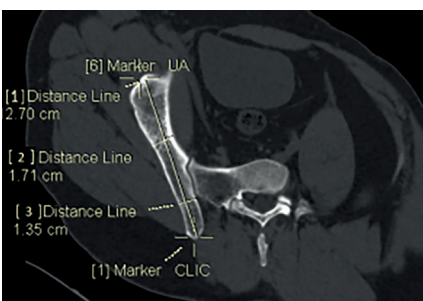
Path C [CLIC point to upper acetabulum (UA)]. Double oblique reformatted CT image showing Path C trajectory; where [1] represents its length, while [2] and [3] represent width of its narrowest zones, [2] being anterior to [3].
